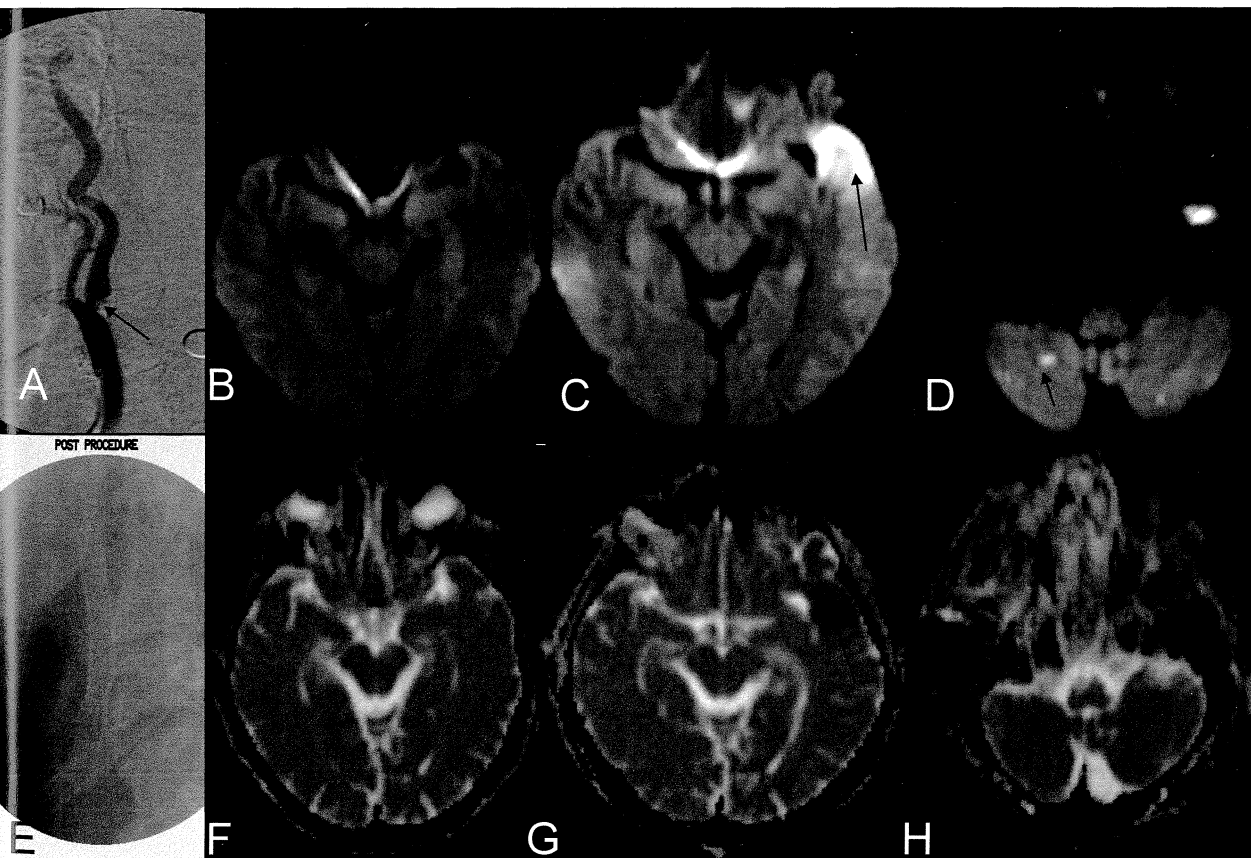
Patient with left ICA stenosis with pre and post procedural images. A and E pre and postprocedure MRA images. B and F are preprocedural DWI images with ADC map. C, G, D and H are postprocedural DWI images with corresponding ADC maps. Note ulcerated plaque (A) in the left ICA with infarct (C and G) in the left temporal pole following procedure. Note silent ischemia in the right cerebellar hemisphere (D and H).
